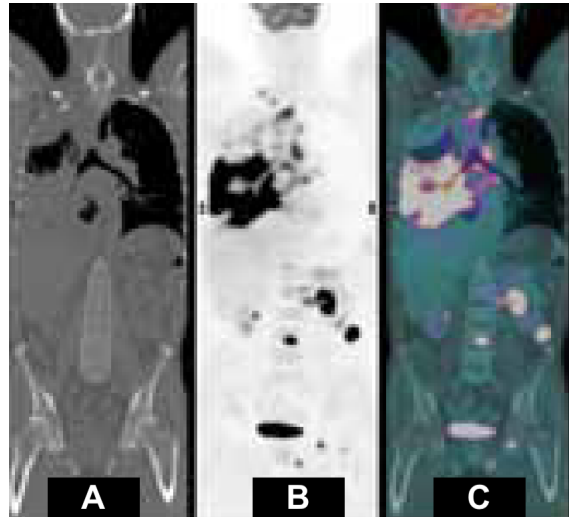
A) CT, B) PET and C) PET overlaid over CT image (adopted from [7]) for a patient with NSCLC (Non-small cell lung cancer).
